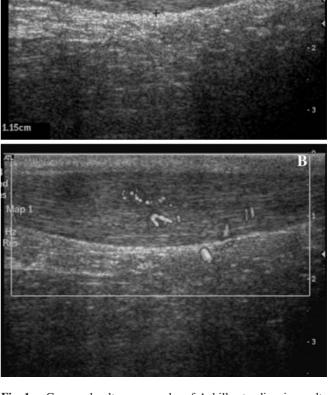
a Grey-scale ultrasonography of Achilles tendinosis resulting in a distinct widening of the tendon (11.5 mm). b Power Doppler ultrasonography of the same Achilles tendinosis with increased blood flow (neovascularisation) intratendinously and anteriorly of the tendon
